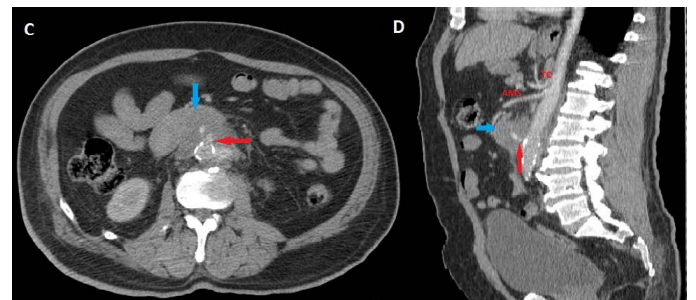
a control abdominal CT scan 10 days after admission with an axial (C) and sagittal (D) objective showing an aneurysmal sac limited anteriorly with the fourth portion of the duodenum (blue arrow) with extravasation of contrast product in the endoluminal (Red Arrow).
